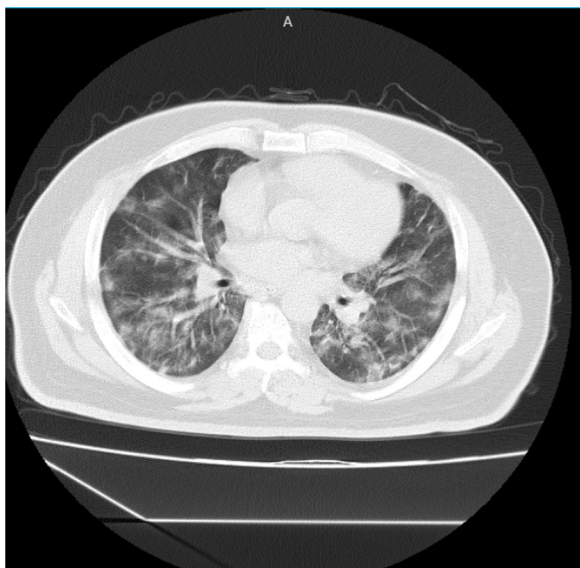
Sagittal computed tomography (CT) image at the time of hospital admission showing widespread patchy ground-glass opacities.
